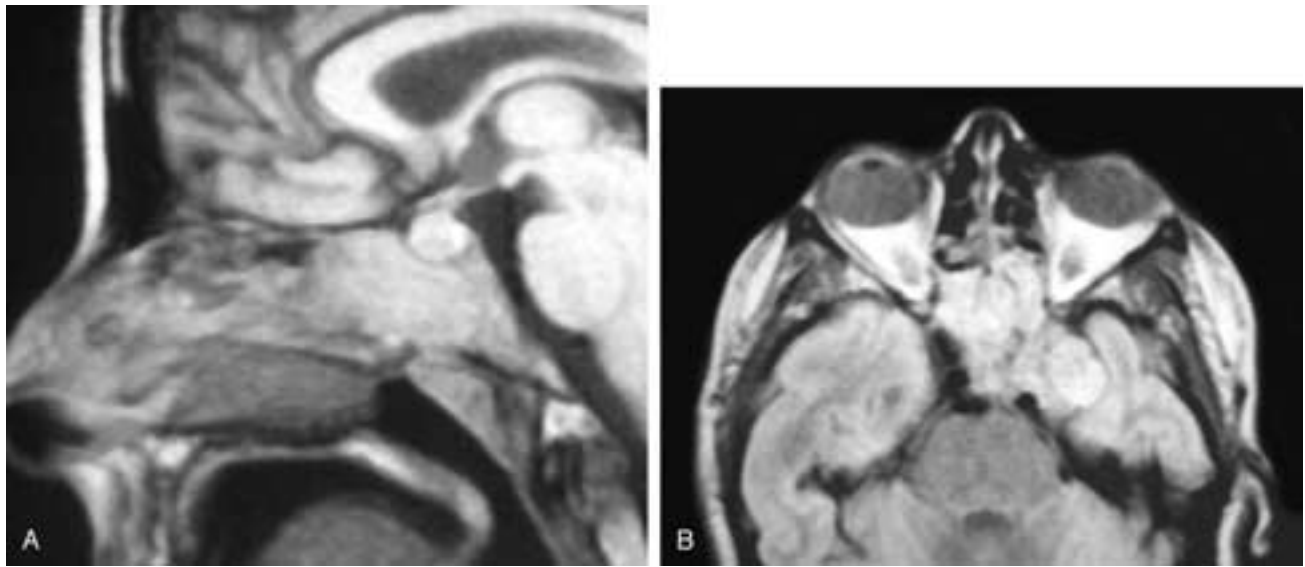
Sagittal (A) and axial (B) T1-weighted MR images show an intermediate signal intensity mass in the sphenoid sinus and clivus with invasion of the left temporal lobe. This patient had a rare metastatic pheochromocytoma.
